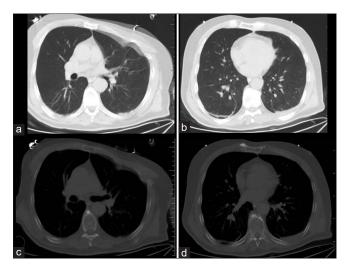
Computed tomography images of patient. (a) Computed tomography image in the lung window showing left hemithorax collapsing in inspiratory. (b) Computed tomography image in the lung window showing left hemithorax rotates equally with the right hemithorax in expiration. (c) Computed tomography image in the lung parenchyma window showing left hemithorax collapsing in inspiratory. (d) Computed tomography image in the lung parenchyma window showing left hemithorax rotates equally with the right hemithorax in expiration
